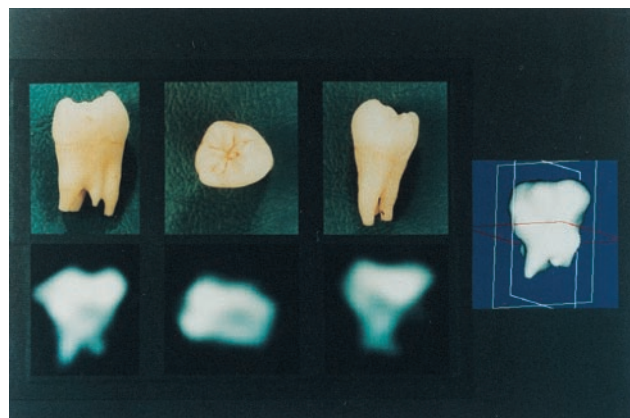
Phosphorus-31 solid-state MRI of a human molar obtained by 3D projection imaging of 998 free induction decays at 2.0 T field strength. The three 2D images are planes of data selected from the full 3D data set. Alternatively, radiographic or dual energy x-ray absorptiometry-like projective views could have been easily shown as well. On the right is shown a solid body representation of the same data set, binary segmented by finding the surface containing all pixels above a threshold value and rendered by Gouraud shading.
